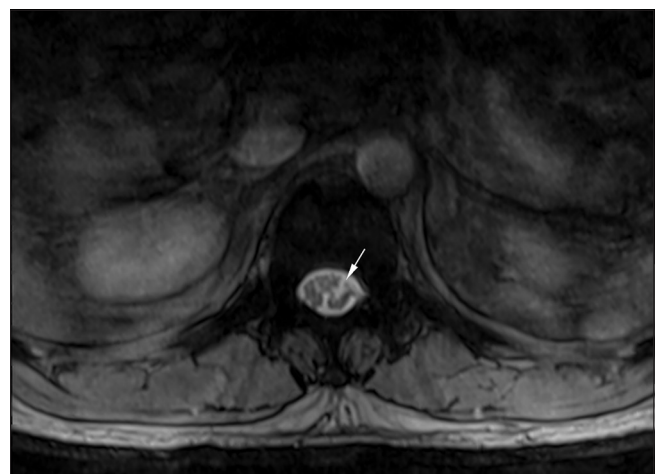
Axial T2-weighted magnetic resonance imaging at T12 vertebral level revealed the occurrence of syrinx within the lower thoracic spinal cord more on the left hemi-cord (white arrow)
